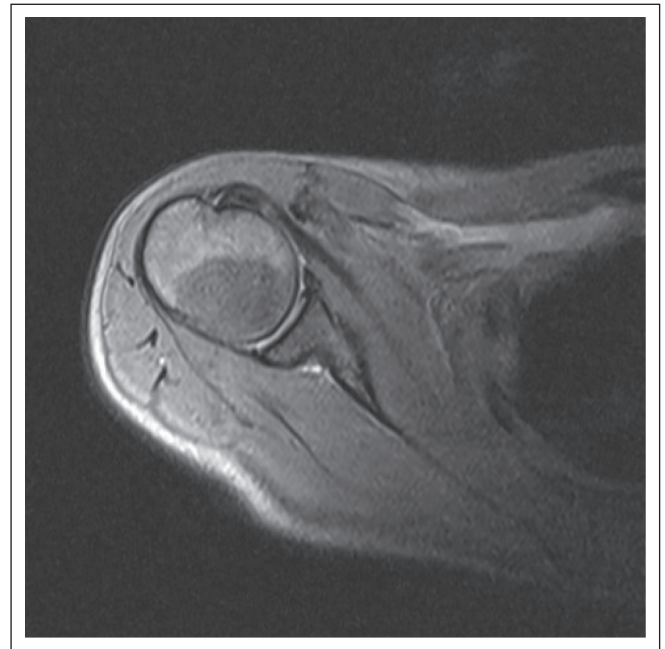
MRI of right shoulder with no evidence of intra-articular effusion or in the synovial prolongment, as well as in the shoulder bursa. There is no evidence of synovitis or joint effusion.
